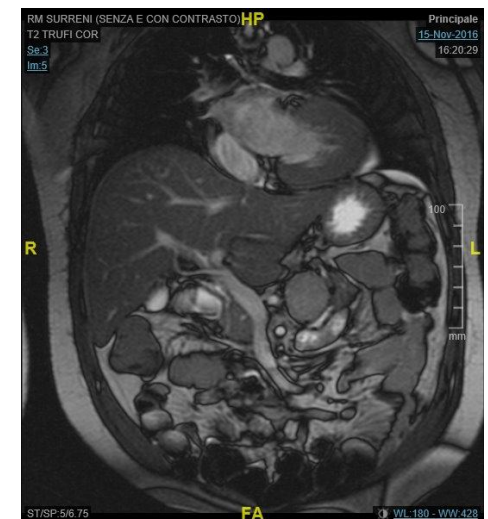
Abdominal MRI showing in the left adrenal loggia the presence of a nodular formation of 53x38mm.
